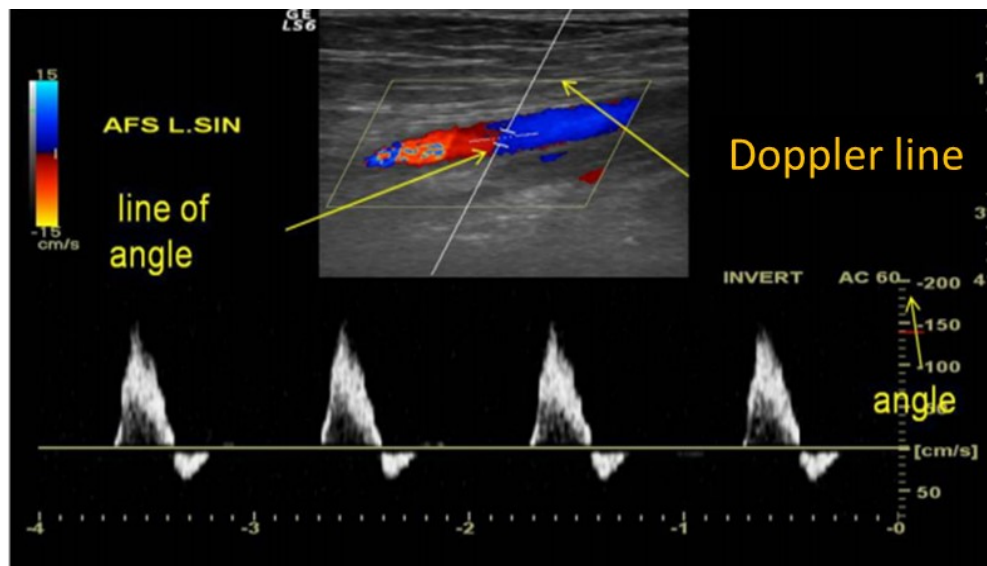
Doppler blood velocity within a sample volume in blood vessel, the orientation of line angle is parallel to blood flow.
